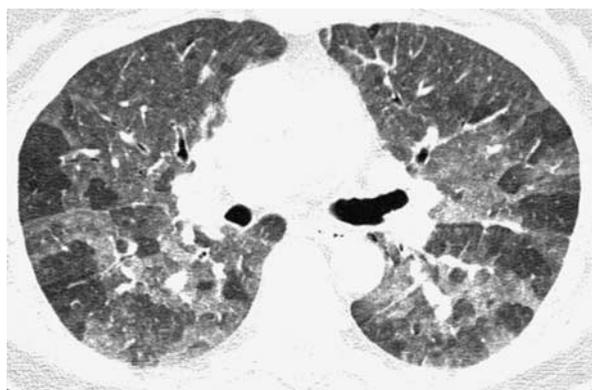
The headcheese sign. Geographic areas of GGO, mosaic perfusion, and relatively normal lung resembling the deli meat headcheese are present on this axial HRCT image. This finding is most commonly seen in patients with HP.
